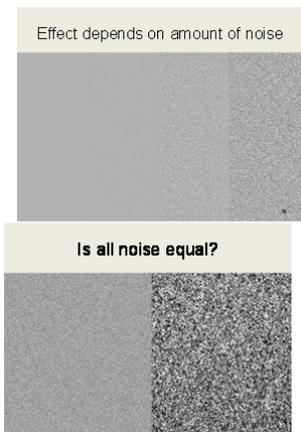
(top) Electronic slides containing image noise of varying levels and frequency characteristics. (bottom) A transparency with disks of varying gray level is held in front of the different noisy “x-ray fields” to demonstrate the change in detectability of “lesions” with noise of different characteristics.
